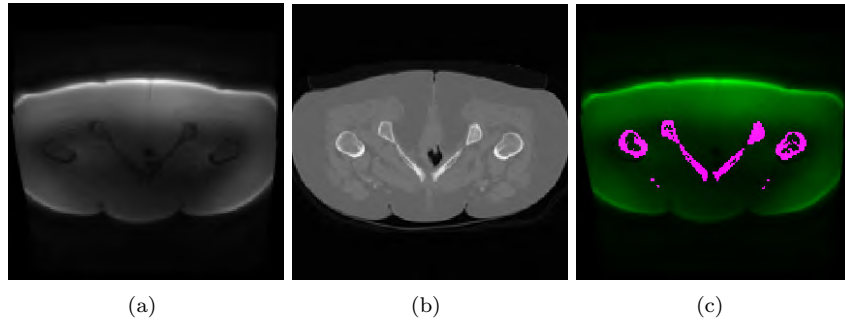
2D registration of ZTE and CT image of the hip based on mutual information. (a) ZTE image, (b) CT image, (c) registration result.
